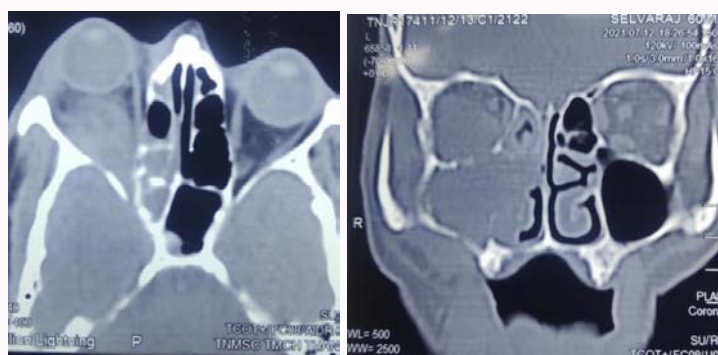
Showing CT PNS image of orbital extension and erosion of wall of maxillary sinus.
